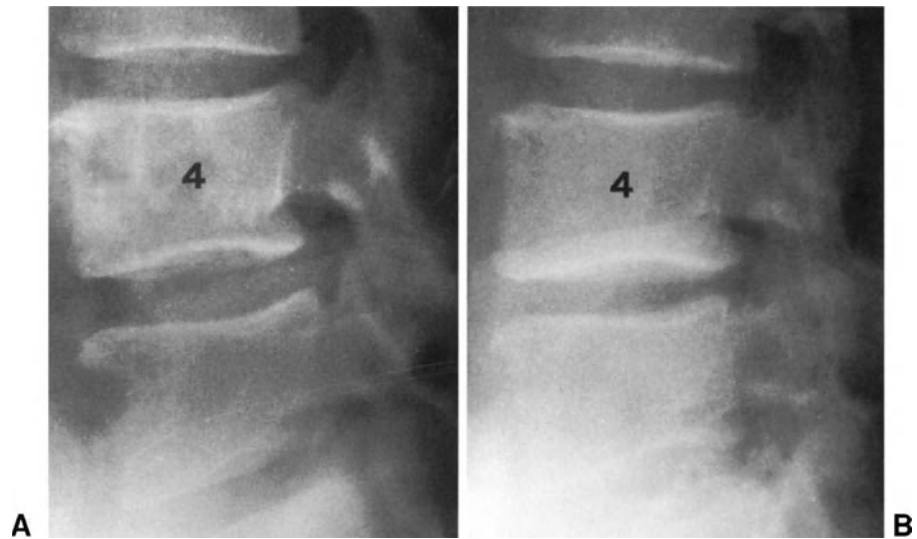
Plain radiographs carried out before chemonucleolysis (A) and 1 month after the procedure (B). Disc height has decreased by about 40% after chemonucleolysis.
